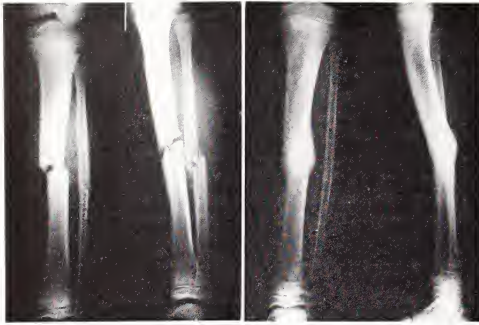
X-rays of original fracture involving both bones (tibia and fibula) of the lower leg in a boy who was struck by an automobile while riding his bicycle. There was an open wound (compound fracture) with marked swelling of the soft tissues.
